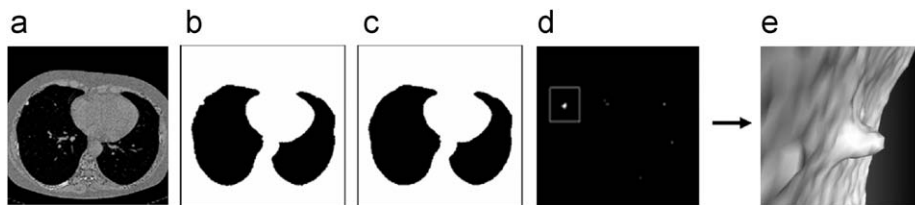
Morphological *opening*-based procedure applied to a CT slice: (a) a slice of the original CT scan; (b) binary conversion of the slice once the pleura has been identified; (c) *opened* image; (d) the image in (c) is subtracted from the image in (b) and (e) shaded surface display representation of one nodule candidate.
